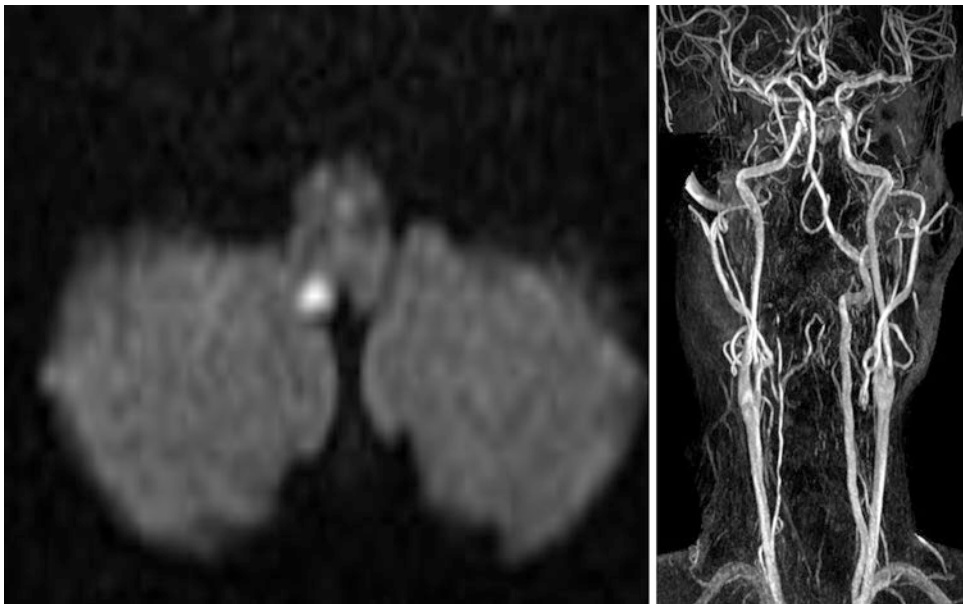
A 69-year-old hypertensive man developed gait instability and numb sensation in the right hand, most markedly in the first-third finger tips. Neurological examination showed slightly decreased position and vibration sensation in the right fingers and impaired tandem gait. Diffusion-weighted MRI (left image) showed dorsally located infarct in the medullary-spinal cord junction.
